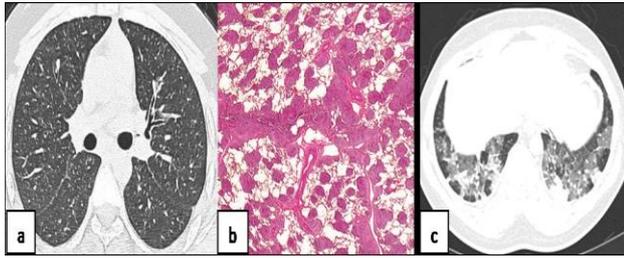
Predominantly nodular findings (a) HRCT image of a patient with sarcoidosis shows small well-defined centrilobular nodules with perilymphatic distribution and symmetrical lymph node enlargement (b) HPE shows extensive pleural and interlobular segments.
